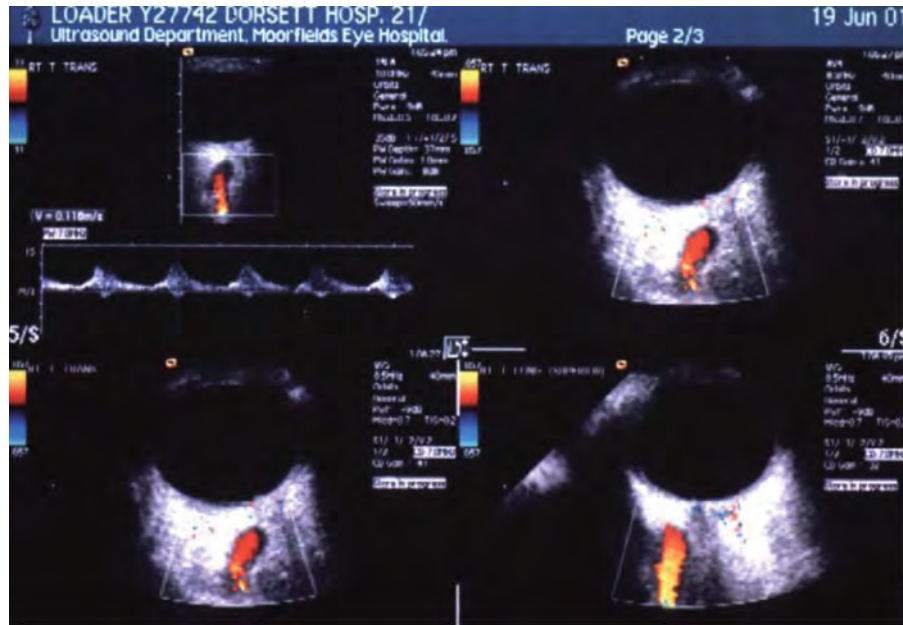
Colour Doppler flow mapping showing flow reversal (red) in superior ophthalmic vein due to carotid-cavernous fistula.
